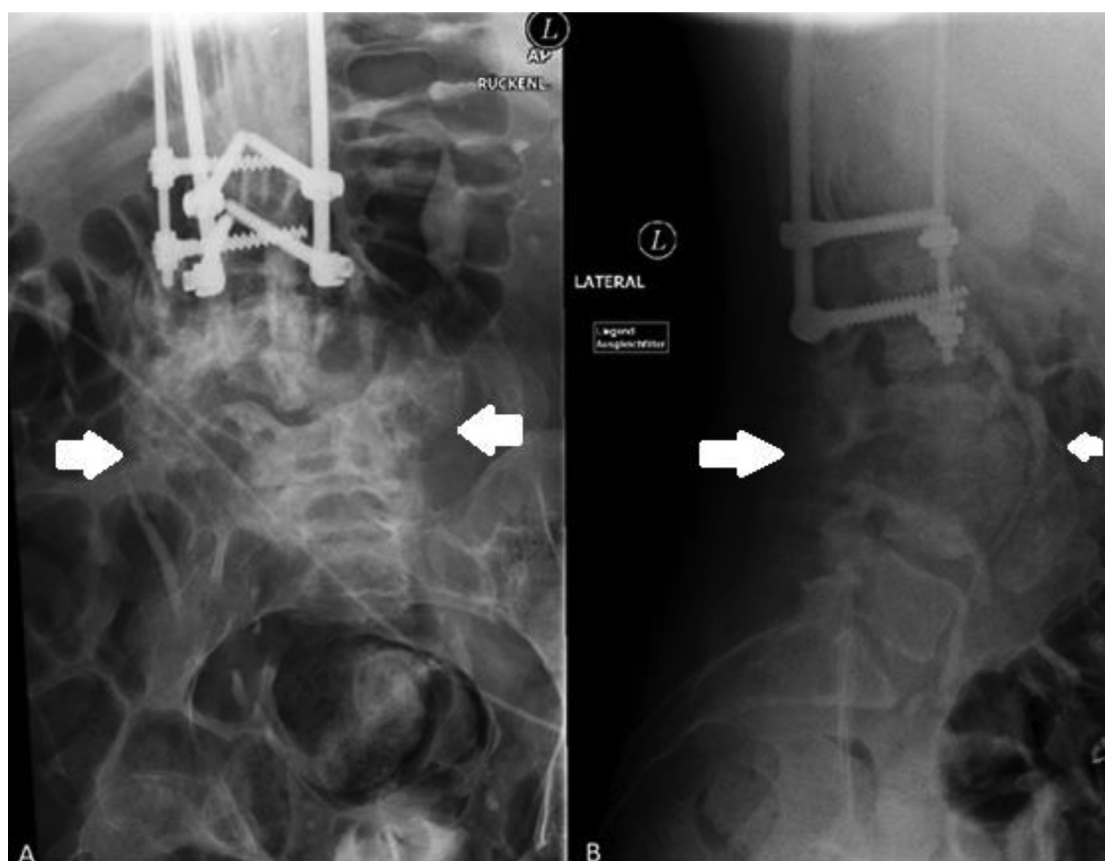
Preoperative lateral (A) and frontal (B) radiographs showing a fused spine at the T8-L2 level with destruction of the L3 and L4 vertebra (white arrow).
